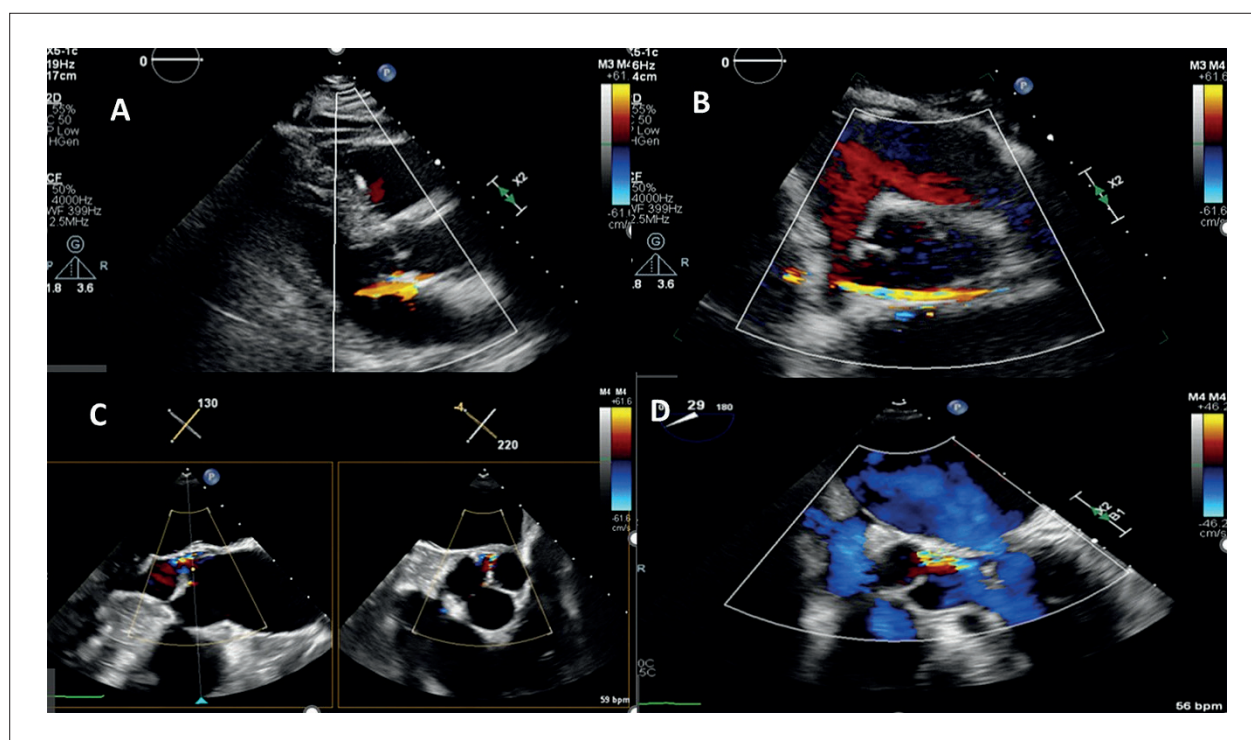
Splay in aortic regurgitation. In the upper images, transthoracic echocardiography in the parasternal long-axis (A) and short-axis (B) views shows evidence of splay, extending beyond anatomical boundaries. In the lower images (C and D), transesophageal echocardiogram reveals an eccentric aortic regurgitant jet originating from the commissural region.
